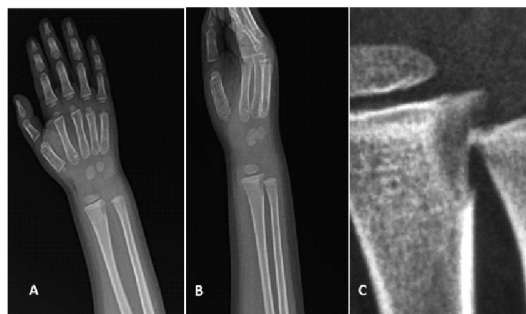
The x-rays done 7 days from the beginning of the symptoms show an osteolytic area at the distal metaphysis of the right radio. No clear rim is present around the lesion. A) anteroposterior view, B) lateral view, C) magnification of the lesion (Rinonapoli G, 2016)
